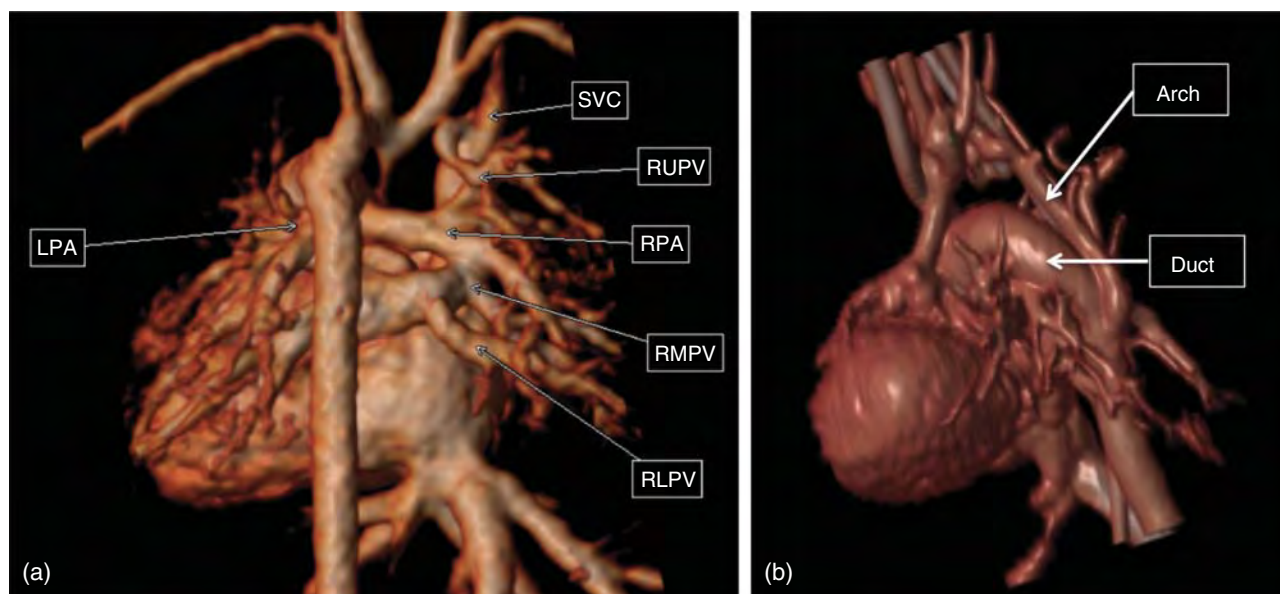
(a) MRI of anomalous drainage of the right upper pulmonary vein to the superior caval vein prior to the Norwood procedure; (b) CT demonstrating very abnormal aortic arch anatomy. LPA, left pulmonary artery; RLPV, right lower pulmonary vein; RMPV, right middle pulmonary vein; RPA, right pulmonary artery; RUPV, right upper pulmonary vein; SVC, superior caval vein.
